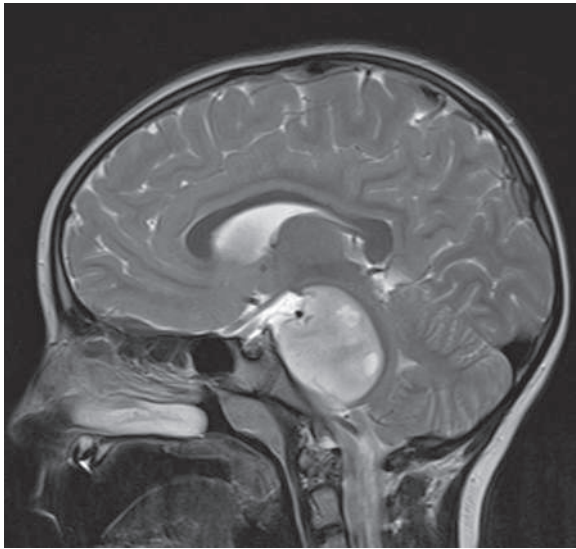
T2-weighted sagittal MR image of a diffuse infiltrating pontine glioma in a 5-yr-old child presenting with headaches, left facial droop, and lethargy.
